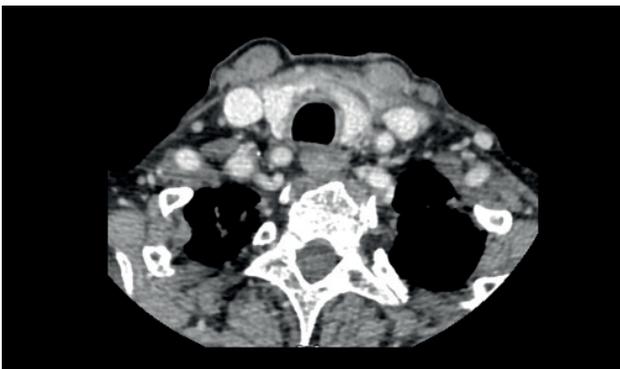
CT scans of the thorax with contrast showed a significant decrease of fluid collections in the anterior region of the neck anteriorly to trachea and in the mediastinal space.
